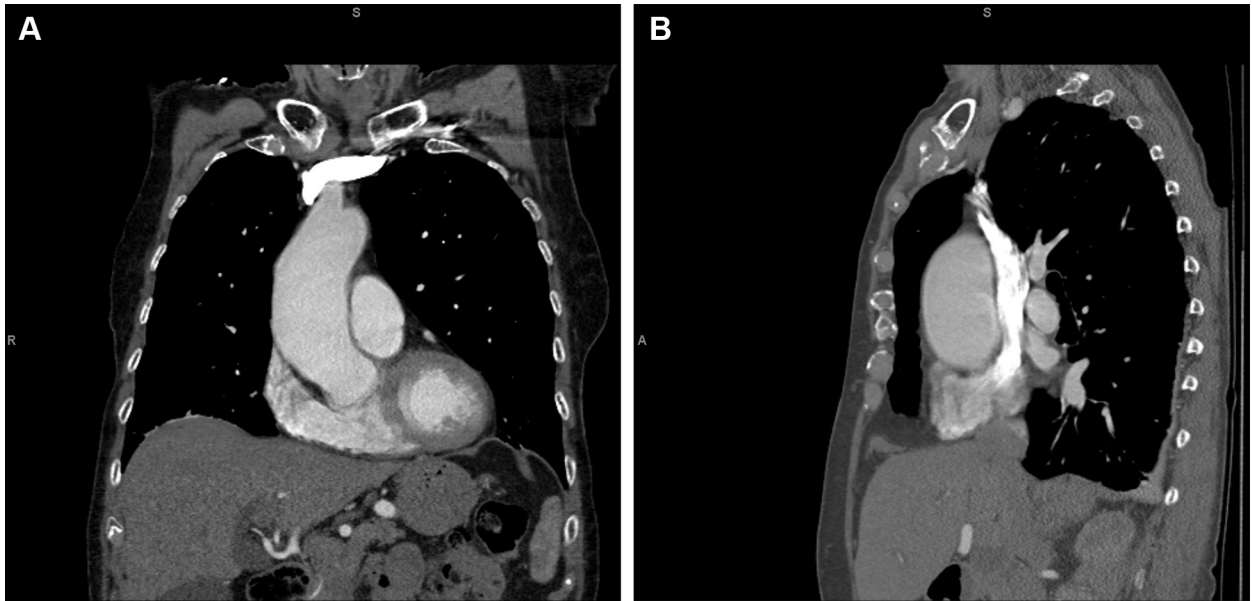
Coronal (A) and sagittal (B) chest CT showing the dilated ascending aorta.
